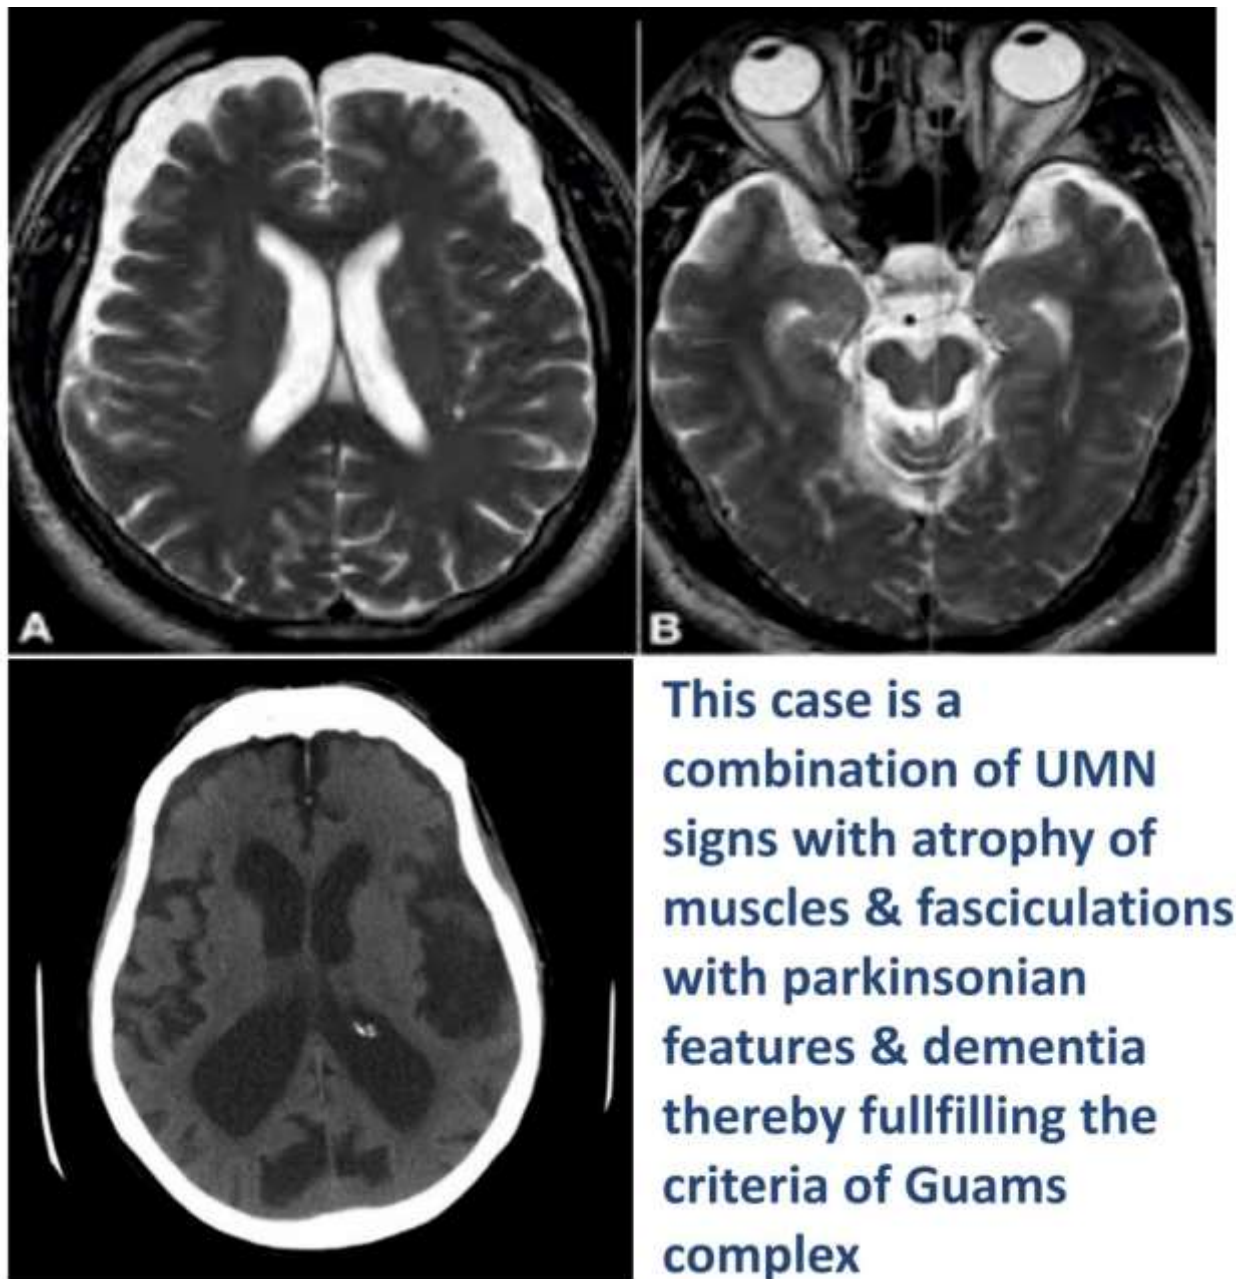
MRI Brain Axial T2 section
